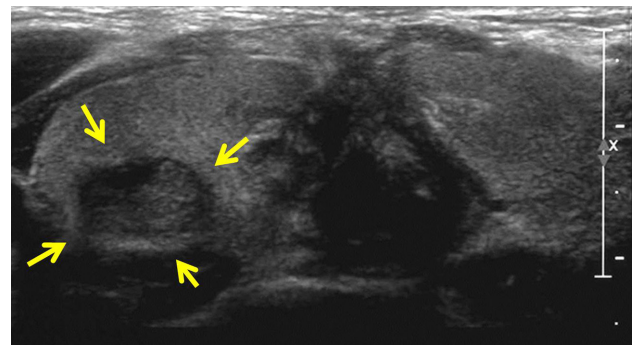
Ultrasonography of the neck in the proband (III-2). A single tumor, 11 × 11 × 6 mm, was found under the right lobe of the thyroid, indicated by arrows.
